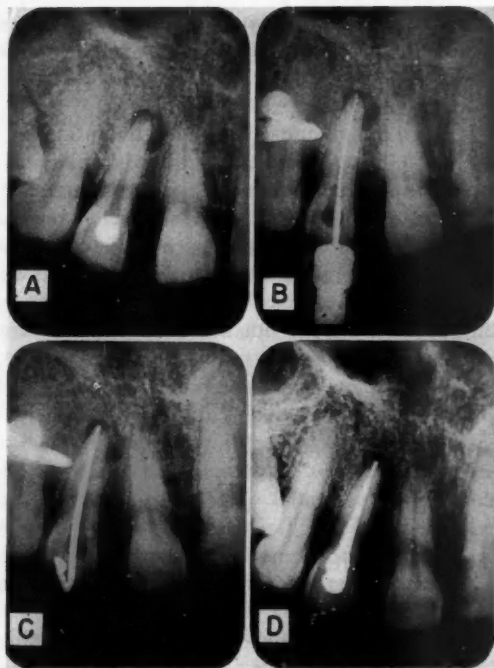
Lateral condensation procedures for filling the canal using a "master" silver point. A, Diagnostic roentgenogram; B, measurement file registering length of the canal; C, master silver point fitted; D, canal filled.
